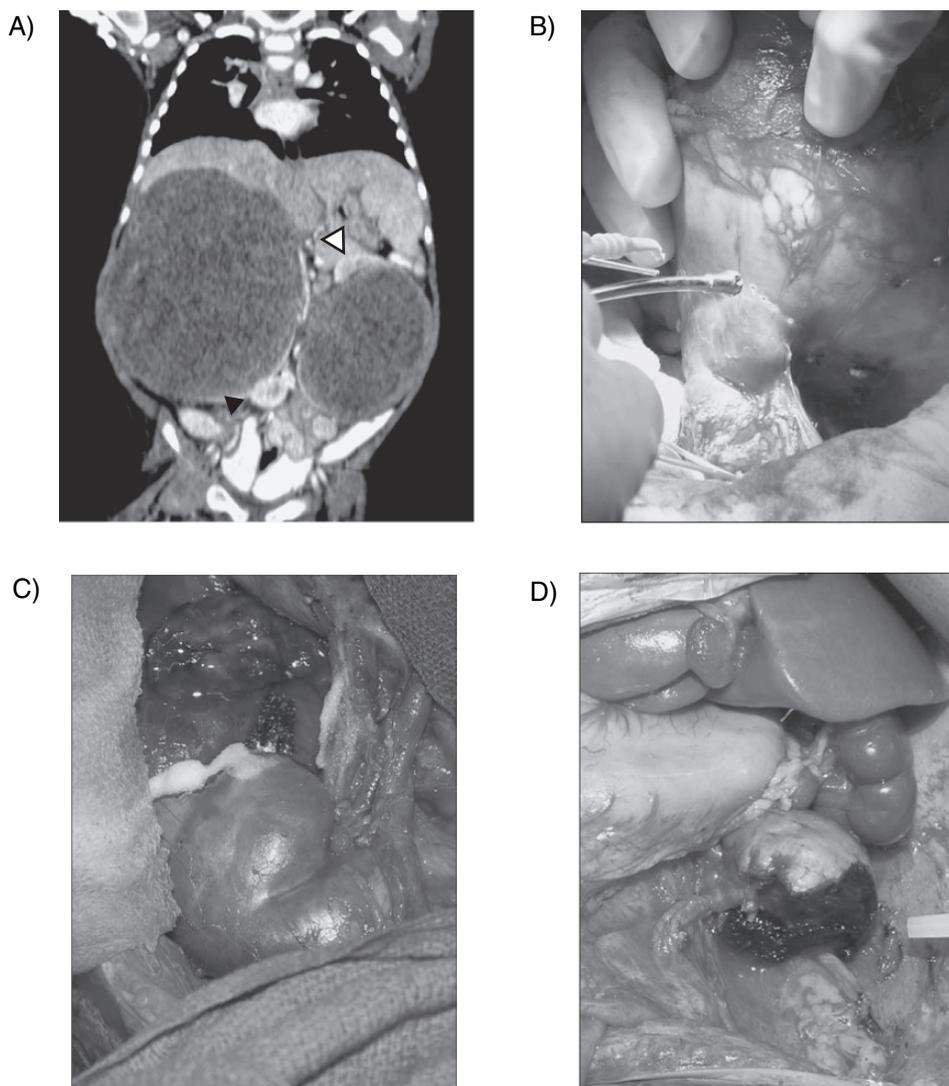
(A) Coronal reconstruction CT scan showing bilateral Wilms' tumors. Normal kidney parenchyma can be seen on the right (black arrowhead) and left (white arrowhead) sides. (B) Intraoperative image showing dissection of the right-sided tumor from the superior portion of the kidney sparing the remainder of the kidney. (C) Right-sided kidney remnant seen *in situ* with cauterized superior margin with Floseal. (D) Left-sided kidney remnant seen *in situ* with cauterized inferior margin.
